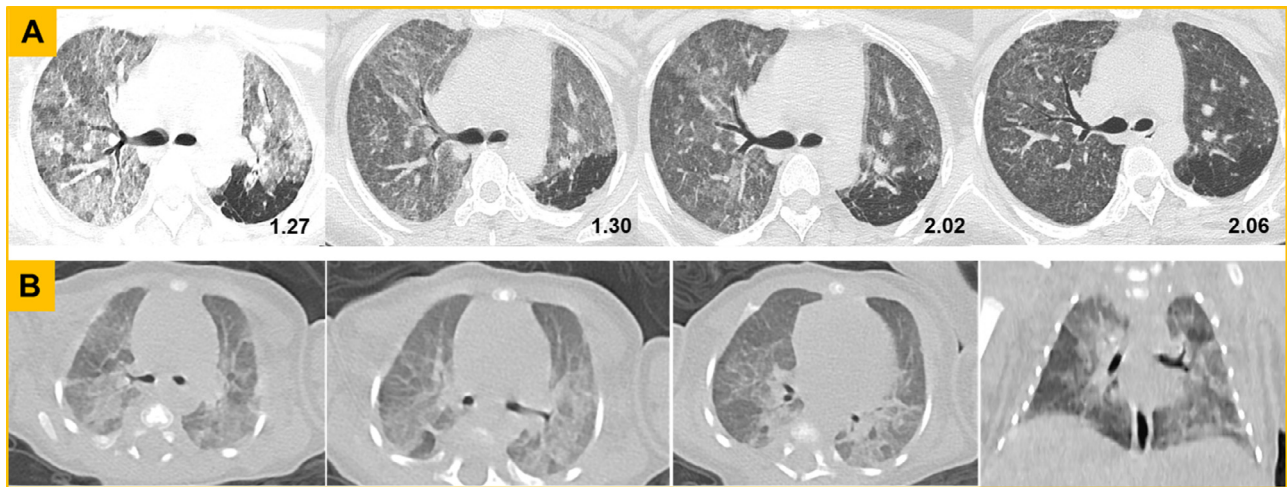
Chest CT screening from the mother (patient 6) and her twin neonate. (A) CT findings from the mother. The first axial image showed extensive ground-glass opacities (GGO) and nodules. On the following days, the intensity decreased, indicating the lesions were gradually absorbed after effective treatment. (B) CT findings from the twin neonate. The axial and coronal images at the nineteenth day of birth presented with extensive GGO along the bronchovascular bundle or in the peripheral area, and the localized consolidation in dorsal segment of right lower lobe.
